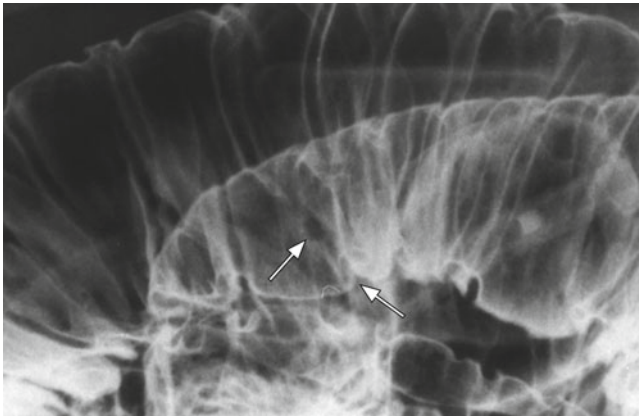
Radiography (small intestinal double-contrast image) showed polyps as small filling defects
